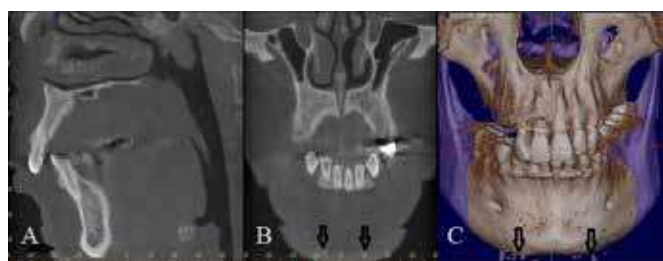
A 45-year-old female referred for implant rehabilitation. On CBCT examination, multiple dot-like radiopaque masses were detected around the chin (arrow). (A) Sagittal view. (B) Coronal view. (C) Three-dimensional reconstruction.
